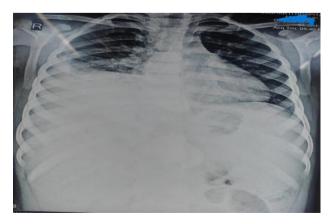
Chest X-ray postero-anterior view showing right sided pleural effusion.
